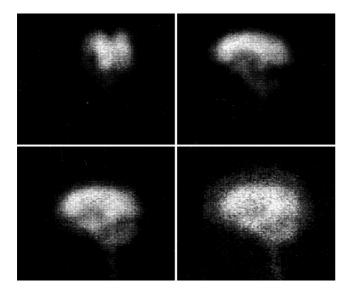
Static scintigrams after 3 hours in anterior view (upper left) and in left lateral (LL) view (upper right) and after 24 hours in LL view (down left) and after 48 hours also in LL view (down right).
